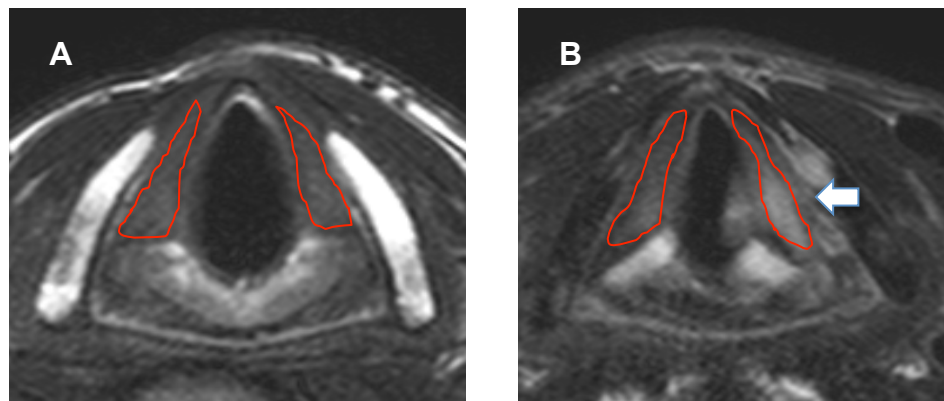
This figure shows T2-MRI of larynx images in axial view showing thyroarytenoid muscles of a: A) healthy volunteer; and B) unilateral vocal fold paralysis patient. The arrow shows left side paralysis in which the signal intensity is higher than the normal side. The region of interests are drawn in redlines.
